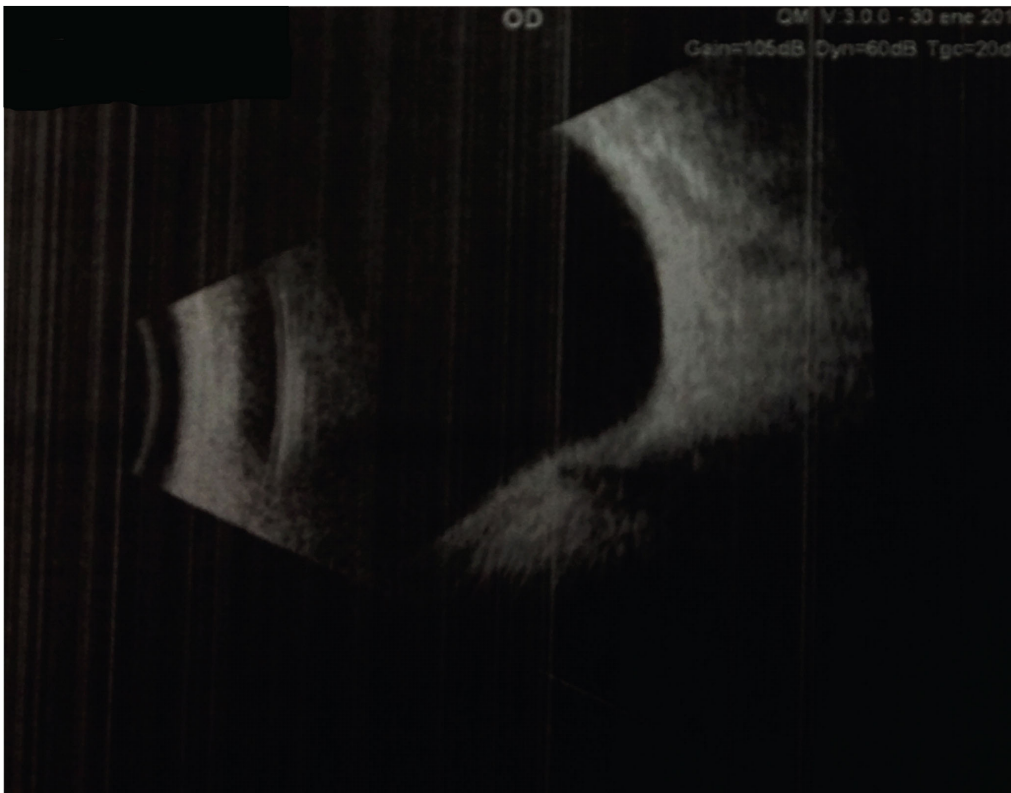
B Scan ultrasound of the same eye as in Figs. (1 and 2). This demonstrates that there is no retinal detachment and an inferior staphyloma is present.
